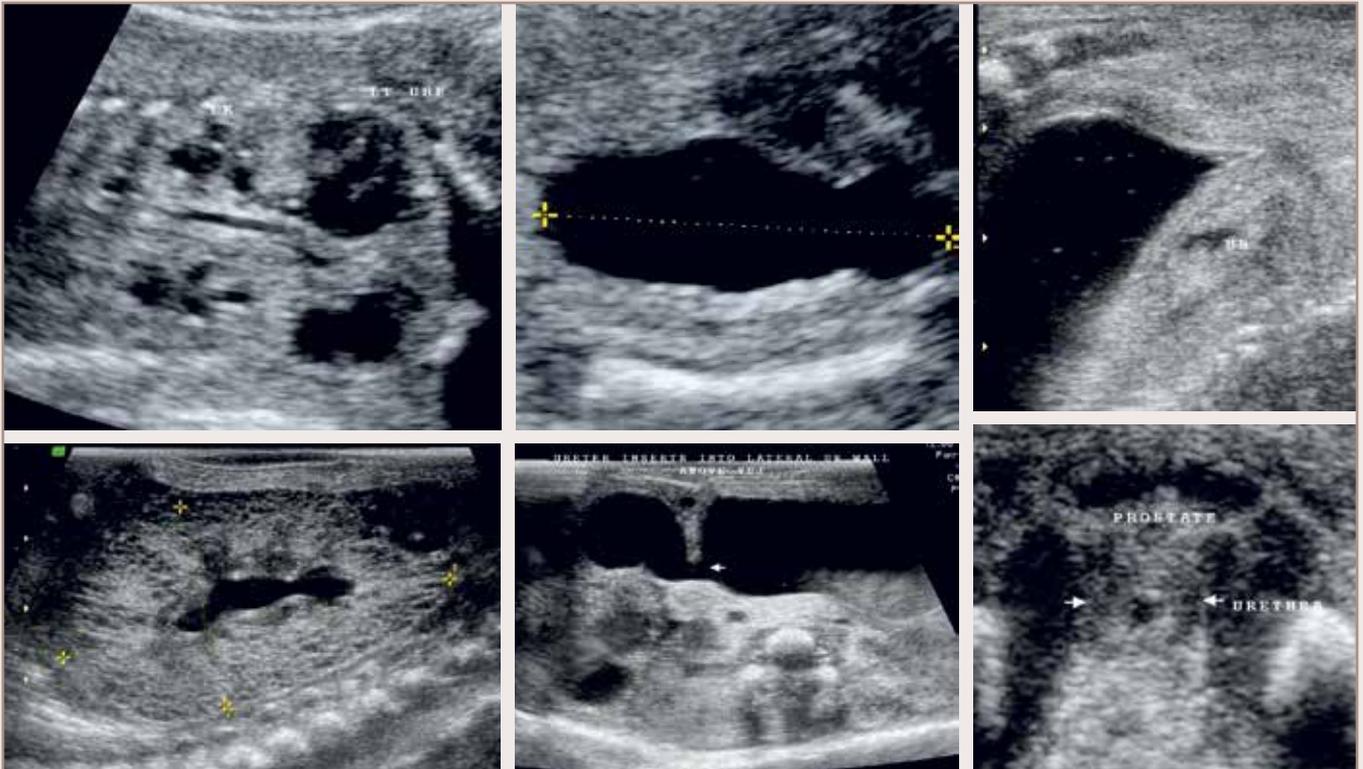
Antenatal Sonography Shows Bilateral Echogenic Kidneys With Hydronephrosis And Dilated Urinary Bladder/ Abortus Sonography Shows Echogenic Kidney With Multiple Tiny Cysts and Dilate Ureter And Dilated Urinary Bladder Abortus Sonography Shows Dilated Urinary Bladder And Dilated Posterior Urethra
